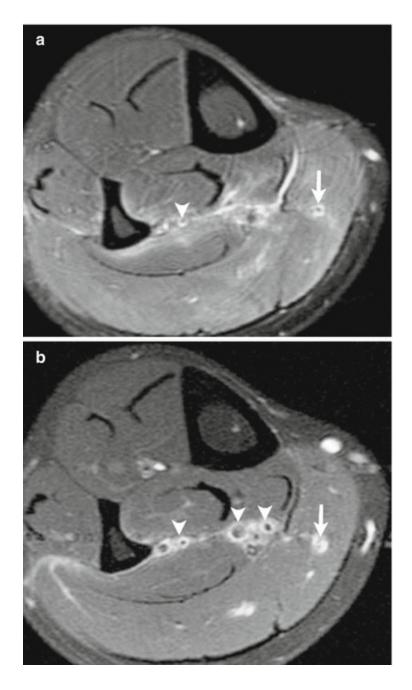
(a, b) Axial fat-suppressed T2-weighted MRI show thrombi within the veins of soleus (arrowheads) and medial head of gastrocnemius muscles (arrow)
